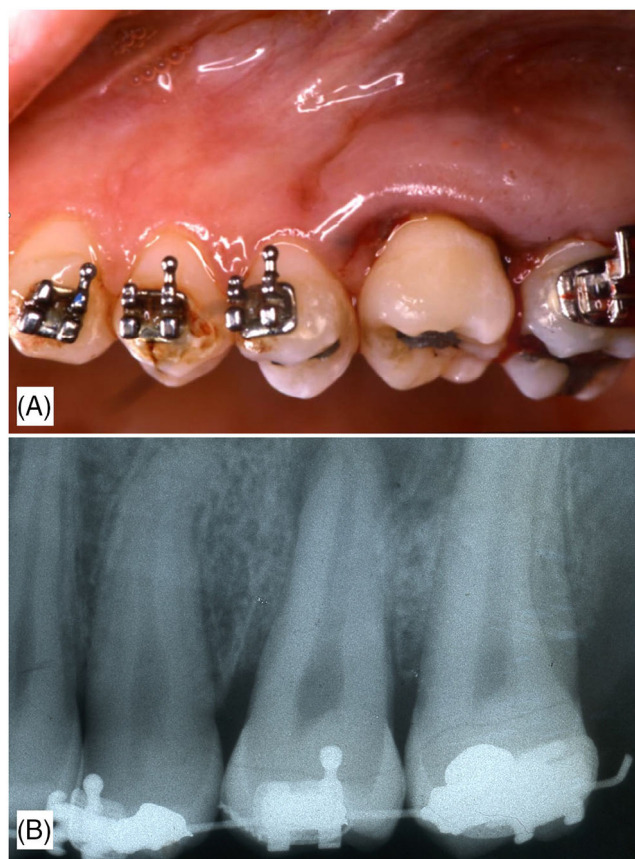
Postoperative clinical (A) and radiographic (B) evaluations after autotransplantation.
